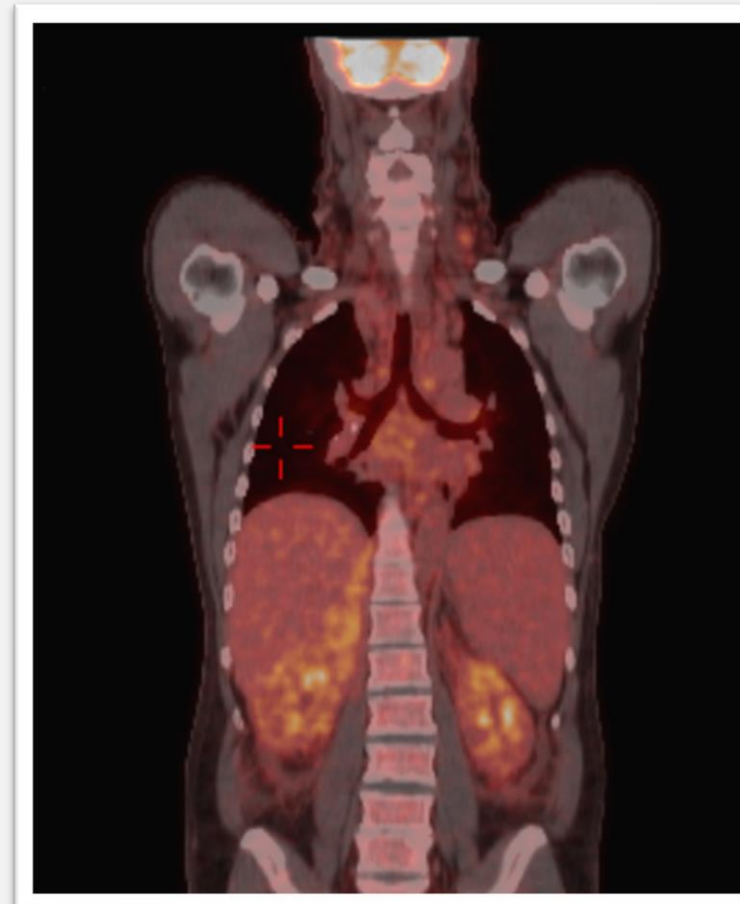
PET CT scan prior to treatment showing Cervical and paratracheal lymph node enlargement.
